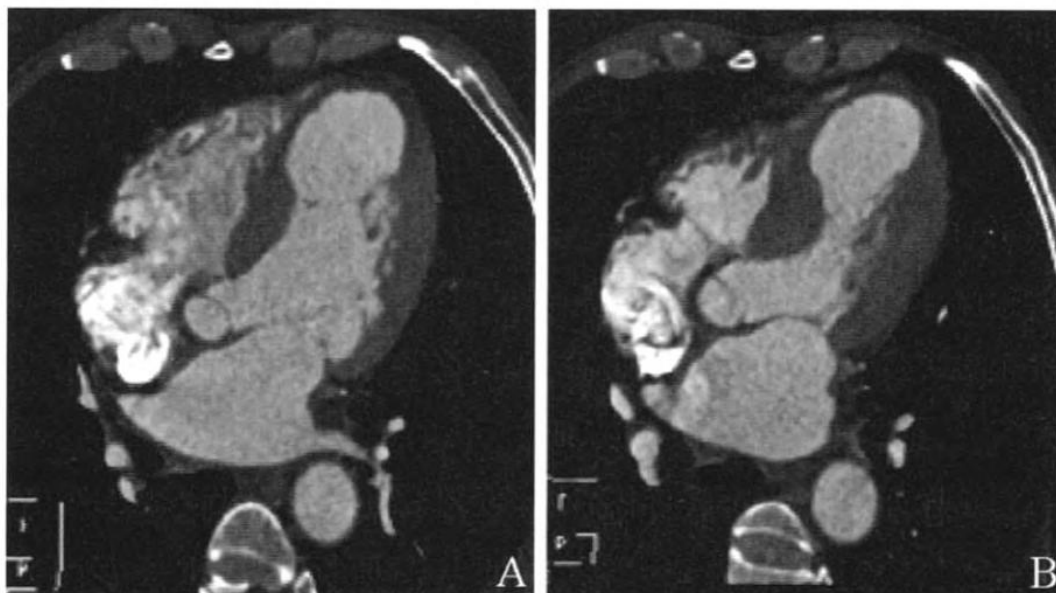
Cardiac computed tomography showed left ventriculograms showing apical akinesis (red arrow) and basal hyperkinesis (white arrow) indicating Takotsubo cardiomyopathy (A - diastolic phase; B - systolic phase).
